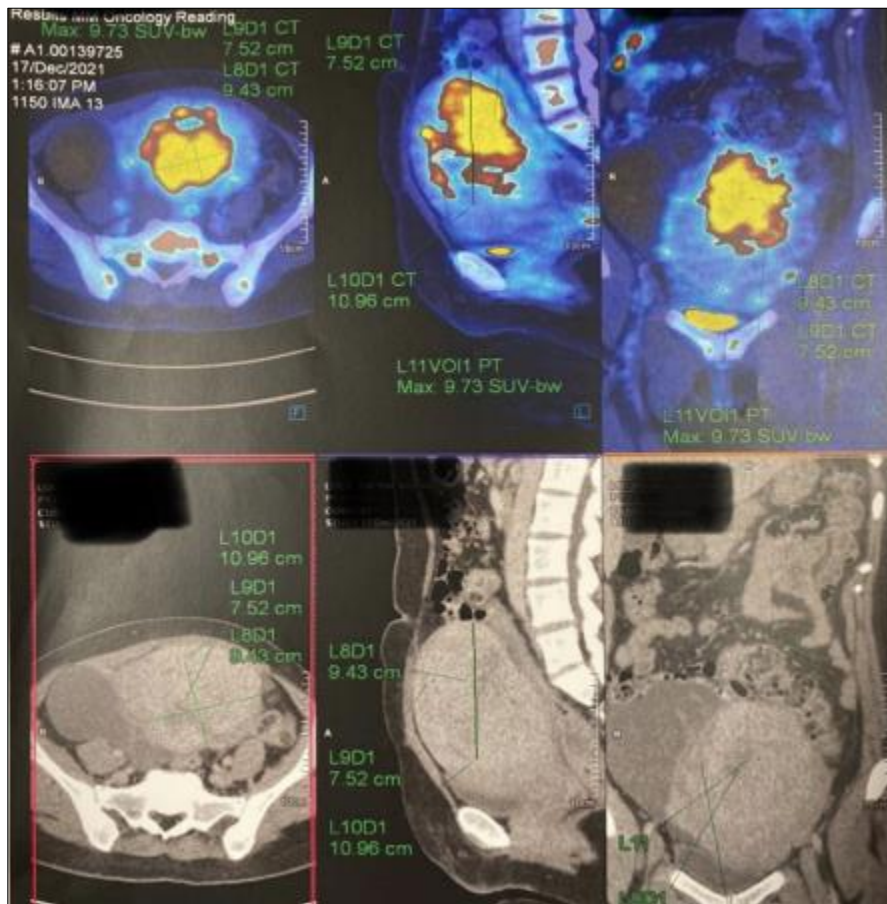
A PET CT showed an enlarged uterus up to the level of the umbilicus. Ill-defined CT hypodense mass with moderate FDG metabolic activity is seen at the posterior uterine wall measuring 9.43 cm x 7.52 cm x 10.96 cm. The radiological features suggested underlying malignant lesions with adenomyoma. The right large multiloculated hypodense cystic lesion (16.96 cm x 9.12cm) showed multiple septations, no internal calcification, no solid component or fat density
